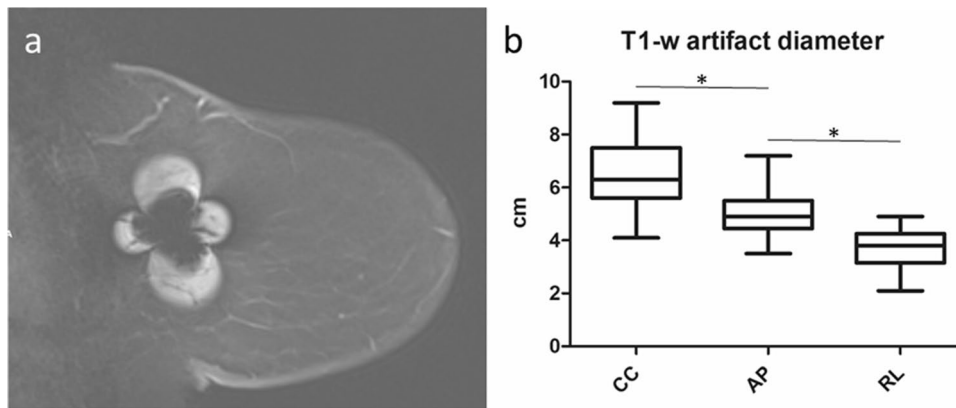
Dipole artifact pattern on subtracted dynamic contrast-enhanced (DCE) T1-weighted images and artifact measurements in the three axes. Sagittal post-contrast T1-weighted image (a) of a representative 69-year-old patient with implantable loop recorder, exhibiting the typical dipole, four-leaf-clover-like artifact with central signal intensity (SI) void and four round high-SI artifacts, prominent
